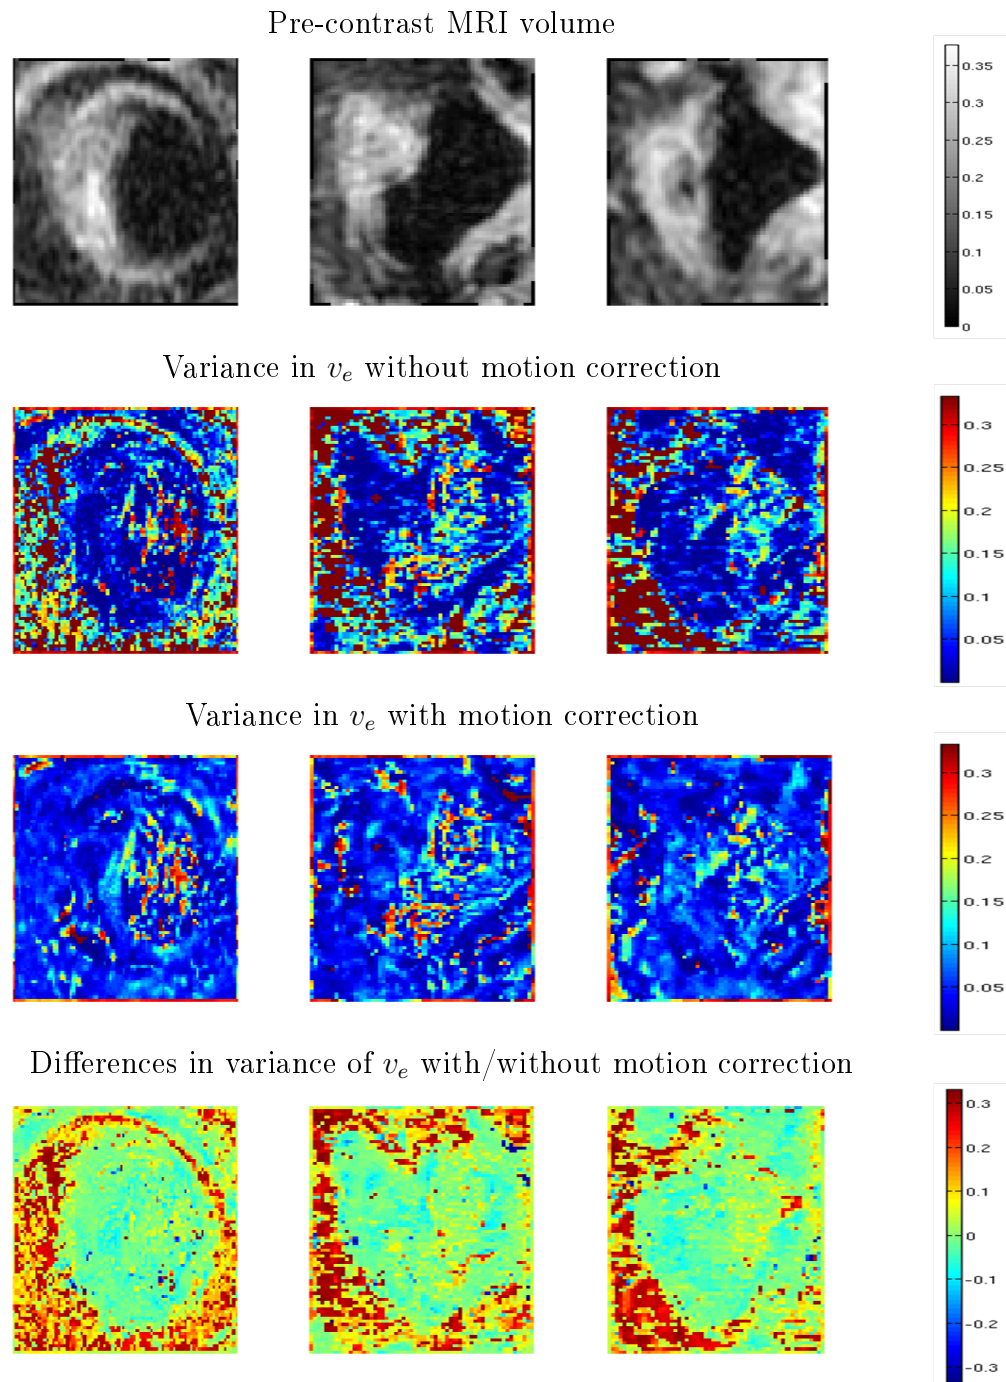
Axial (left column), coronal (middle column) and sagittal (right column) slices through the pre-contrast MRI volume (top row), and the maps showing the variance in v_e for clinical data, estimated without motion correction (second row), with motion correction (third row), and their difference (bottom row).
